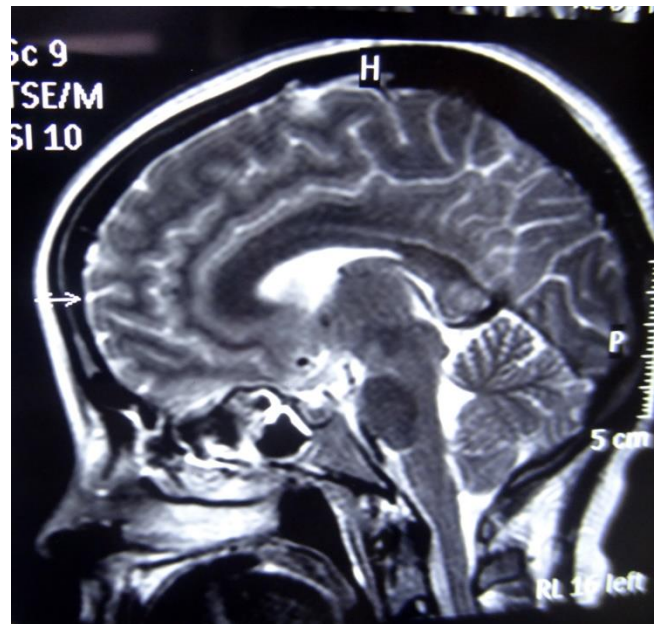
showing T2W MRI image with hyperintensity noted in corpus callosum
